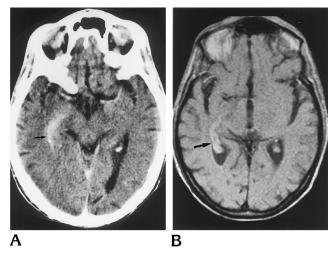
A*, Postcontrast computed tomogram shows marked enhancement of a slightly enlarged right choroid plexus (*arrow*). *B*, Enhanced axial spin-echo T1-weighted (500/20) magnetic resonance image (0.5 T) 2 days later. Pathologic enhancement is seen in the right choroid plexus (*arrow*) without enhancement of ependyma or periventricular edema.
